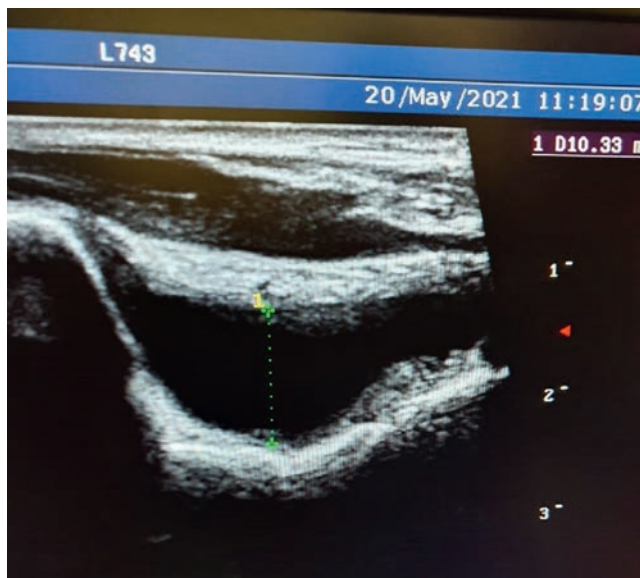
Ultrasonography of the left elbow joint revealing moderate effusion in the left elbow fossa
